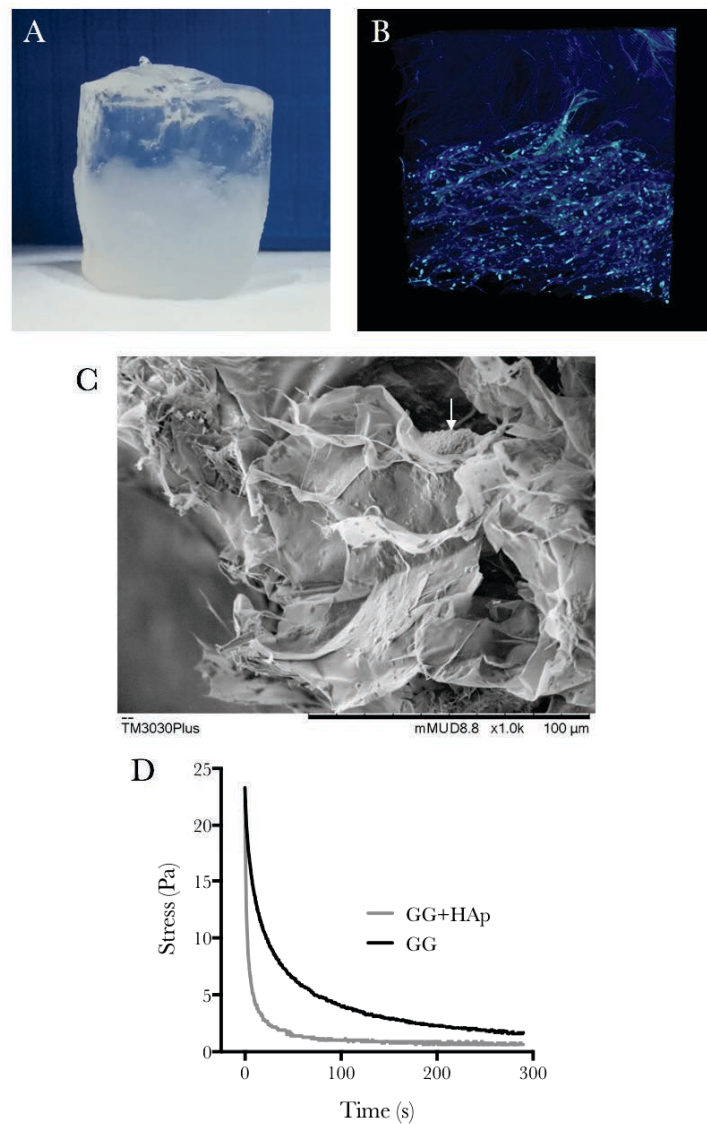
Introduction of mineral for production of bi-layered constructs. A) Gellan/Gellan-HAp construct. B) μ CT reconstruction of a bi-layered construct. C) SEM of HAp integrated into gellan structure, arrow indicates aggregated HAp. D) Stress relaxation behaviour of gellan (GG) and GG-HAp constructs.
